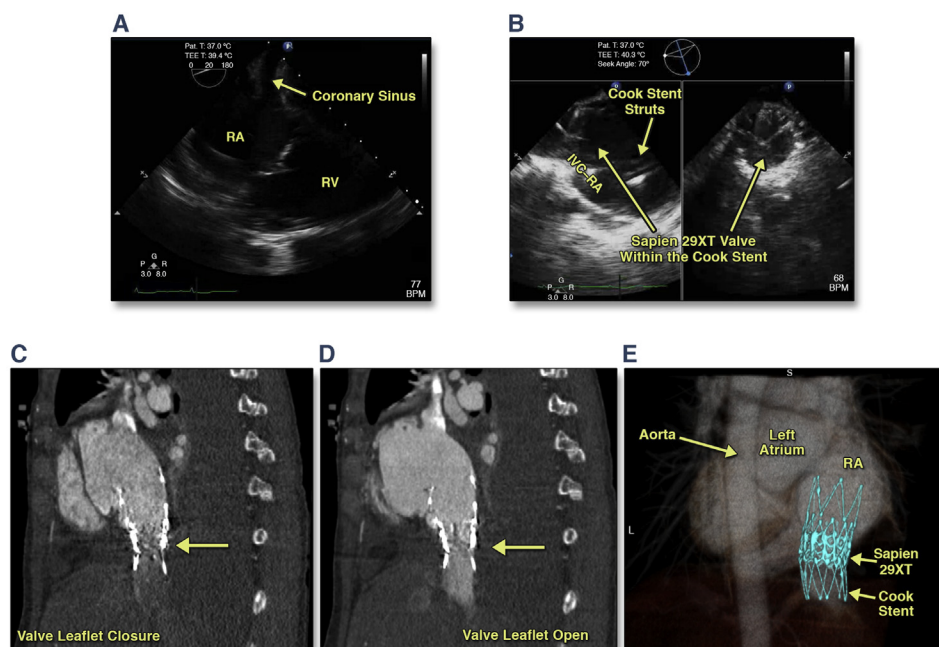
Computed Tomography and 3D Print Guided Selection of the SAPIEN 29XT Valve for Caval Valve Implantation
